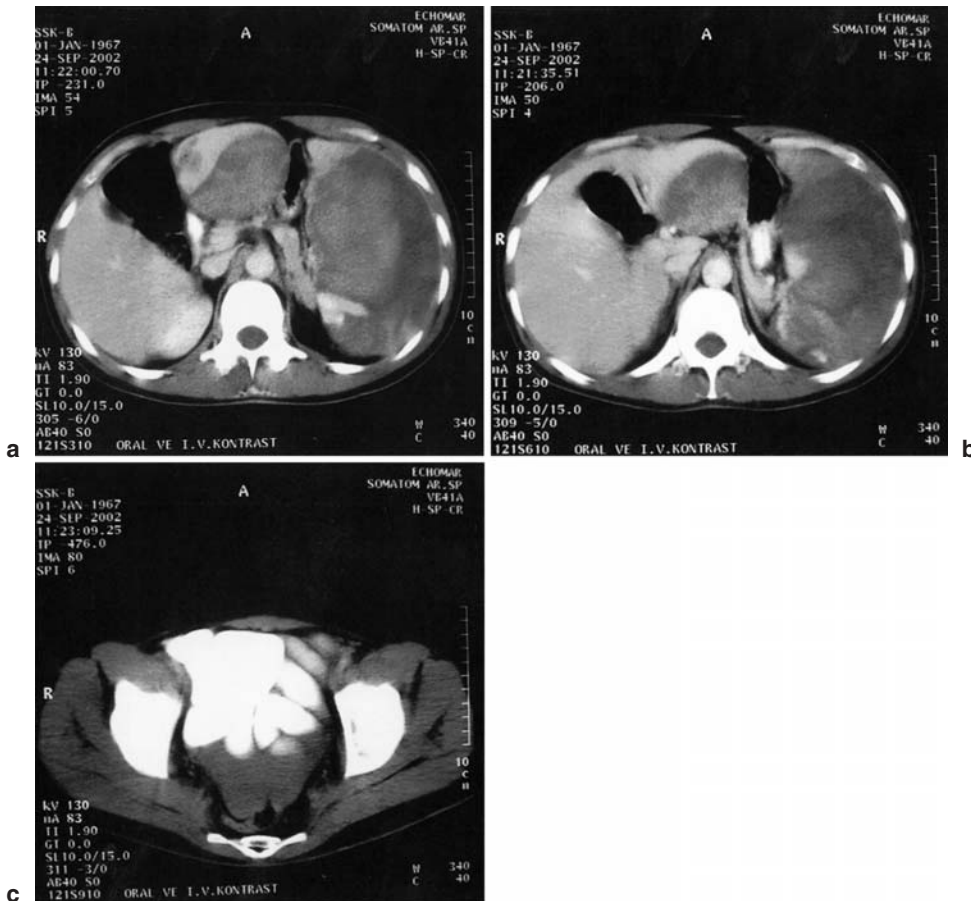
Computed tomography. a A splenic hematoma. b A hepatic and splenic hematoma. c Free fluid in the Douglas pouch
